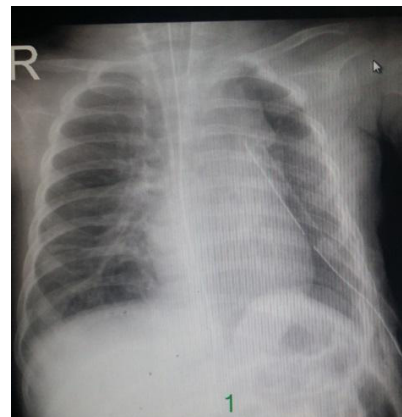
Chest x-ray after repair of congenital left diaphragmatic hernia
